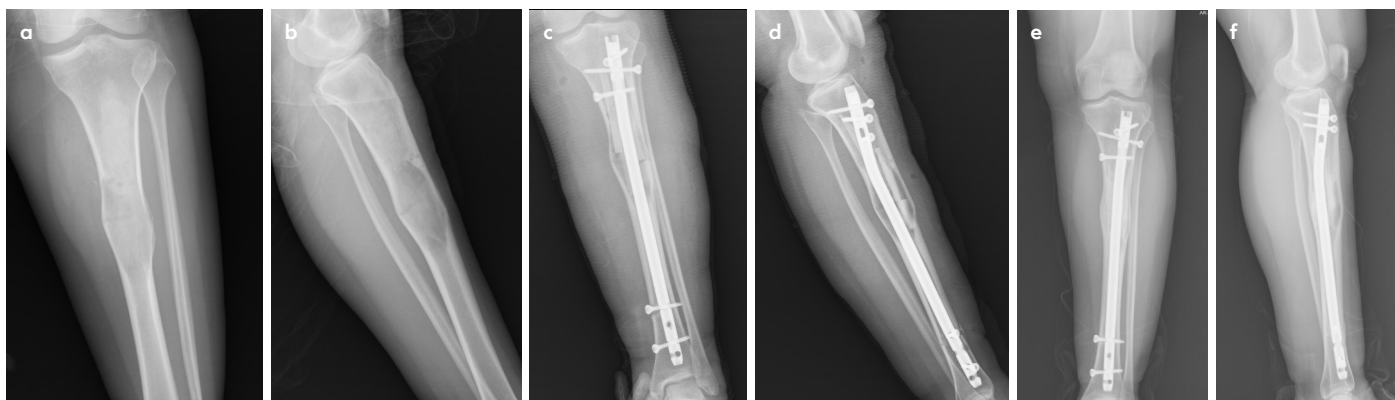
a-f. A 20-year-old girl with severe pain; left tibial lesion. (a, b) Preoperative X-rays; (c, d) Postoperative X-rays; (e, f) X-rays 60 months after surgery
